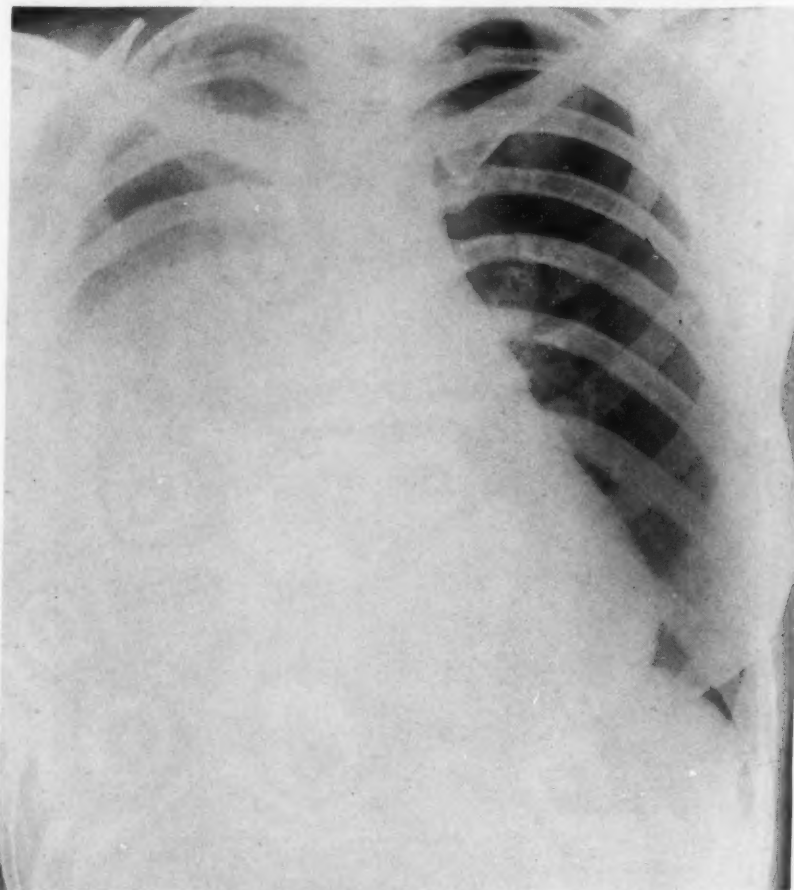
Case 12, Table II: Postero-anterior roentgenogram, taken on admission to hospital, demonstrating the right pleural effusion.
